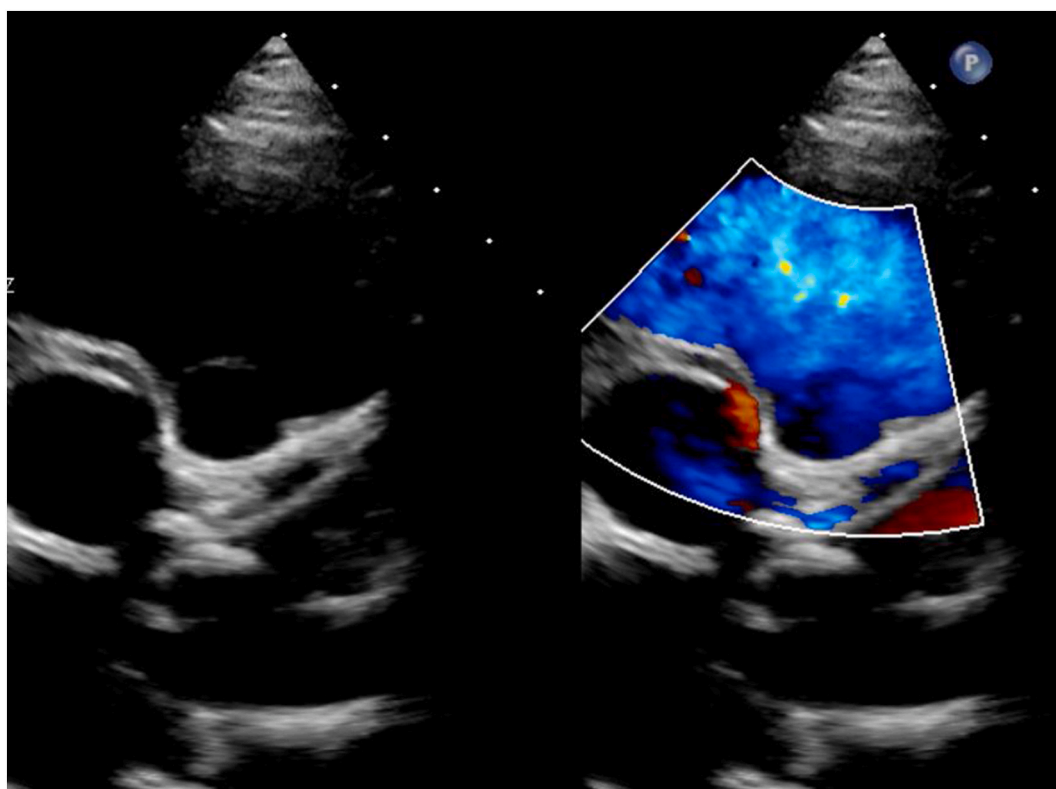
Anomalous aortic origin of the right coronary artery from the left sinus of Valsalva, with an intra-arterial and intramural course. A red linear Doppler flow pattern is seen along the aortic wall consistent with an intra-arterial and intramural course. This diagnosis was confirmed with a coronary computed tomographic angiography (CTA).
